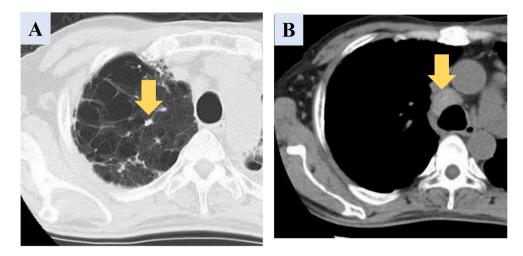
Four months after surgery, computed tomography showed reduction of the (A) lung tumor and (B) mediastinal lymph node.
